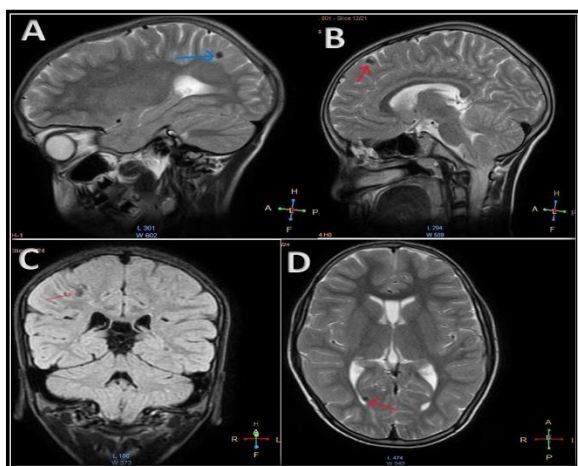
(case 1) T2 (A, B, D) and FLAIR (C) showing low signal intensity suggestive of calcified stage of NCC. T2 (D) showing calcified NCC in posterior horn of right lateral ventricle
